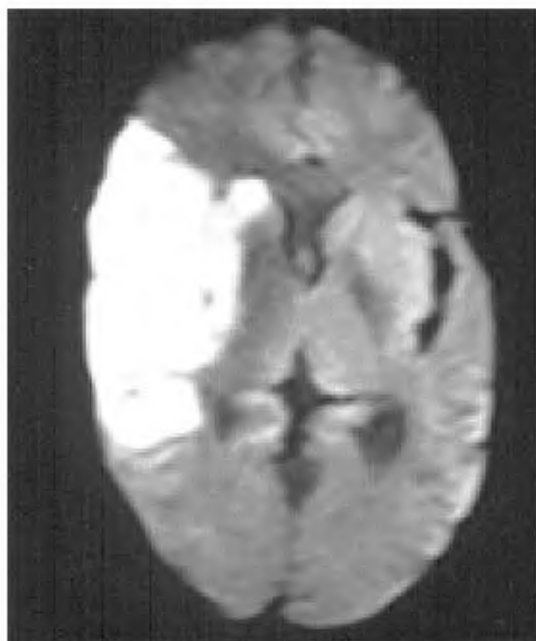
Diffusion-weighted MR image of a patient investigated 6 h after ischaemic stroke. The infarct region is seen clearly as hyperintense area in the right occipital region.
